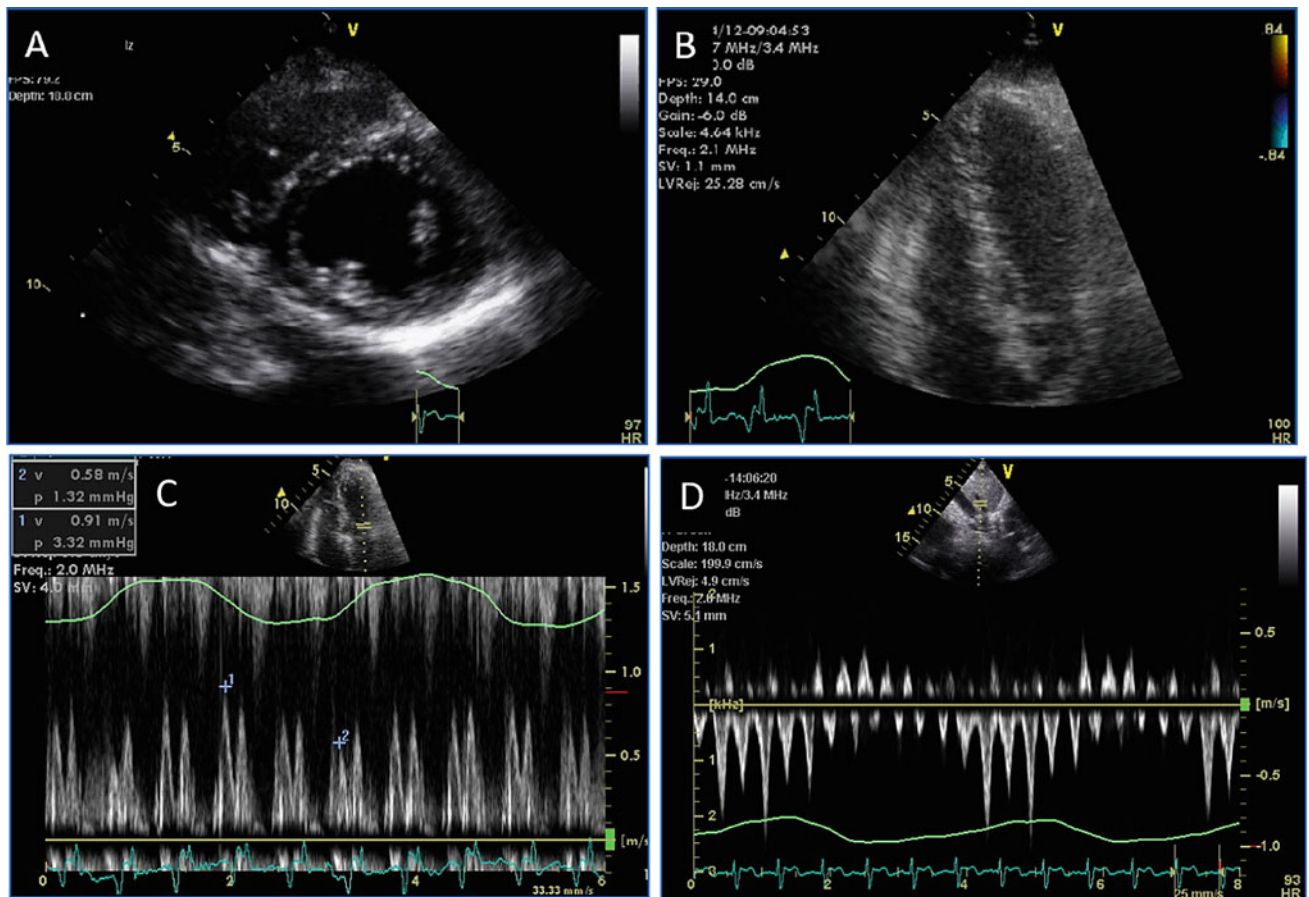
Hemodynamics of constrictive pericarditis as a result of the dissociation of the intrathoracic and intracardiac pressures and exaggerated ventricular interdependence in diastolic filling. a Parasternal short axis view showing prominent septal bounce (see Video 26.3 left panel). b Apical 4 chamber view showing interventricular dependence
